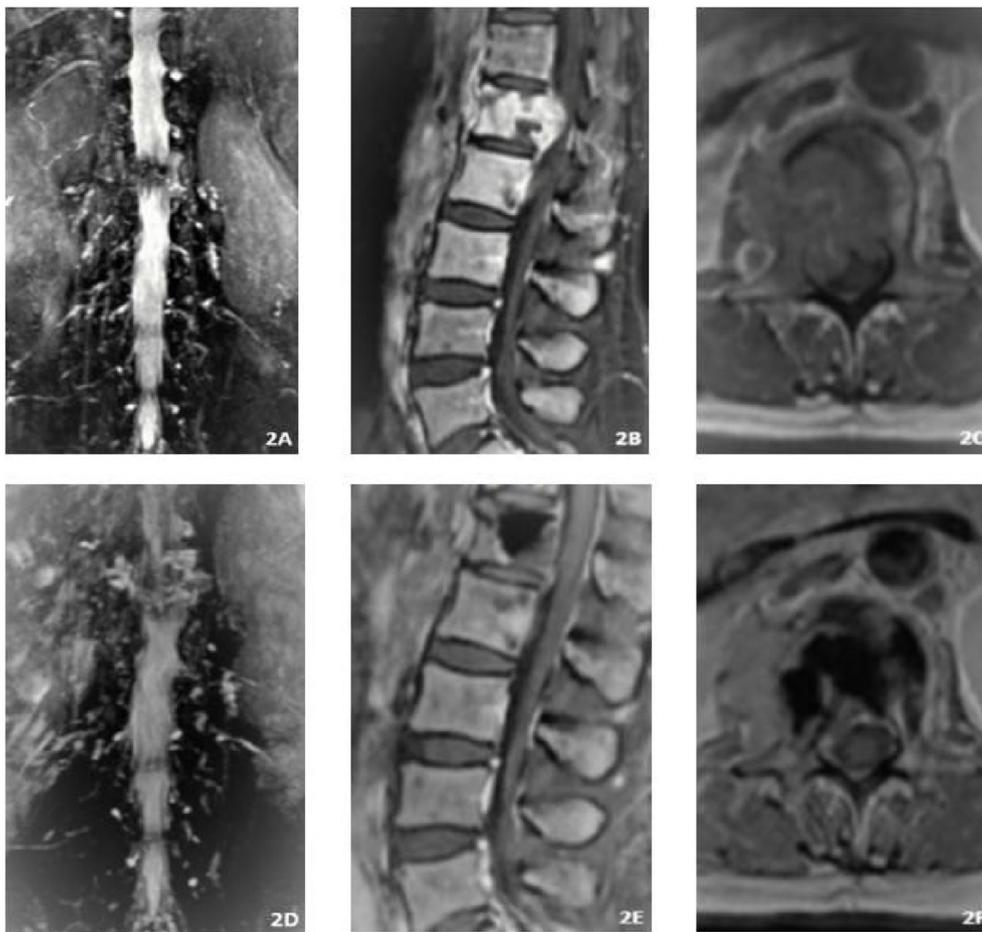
Imaging data for PVP combined with ^{125}I seed implantation in the treatment of bone metastasis of liver cancer. (2A), (2B), and (2C) MIP images of preoperative lumbar MRI and sagittal and transverse T1WI showing the formation of abnormal soft tissue masses in the L1 vertebral body and right adnexa, and severe spinal stenosis caused by compression of the dural sac; (2D), (2E), and (2F) MIP images with enhanced lumbar MRI and sagittal and transverse T1WI obtained 3 months after the operation showed that the soft tissue mass in the spinal canal was significantly smaller than that before the operation, and the compression of the spinal cord was significantly reduced.
